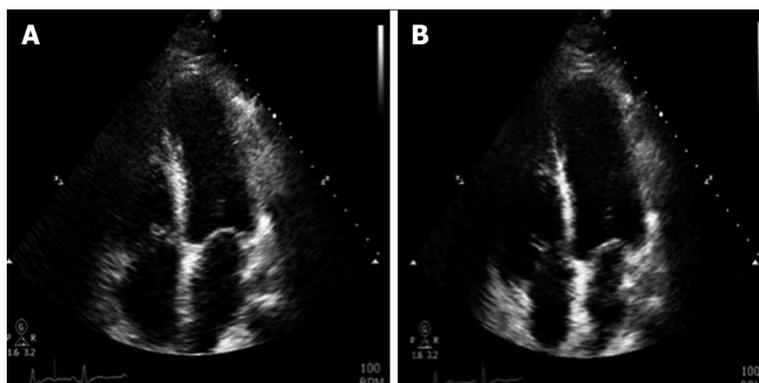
Echocardiogram showing ballooning of the apex with hyper contracted basal segment at end systole (A) end diastolic phase (B).
